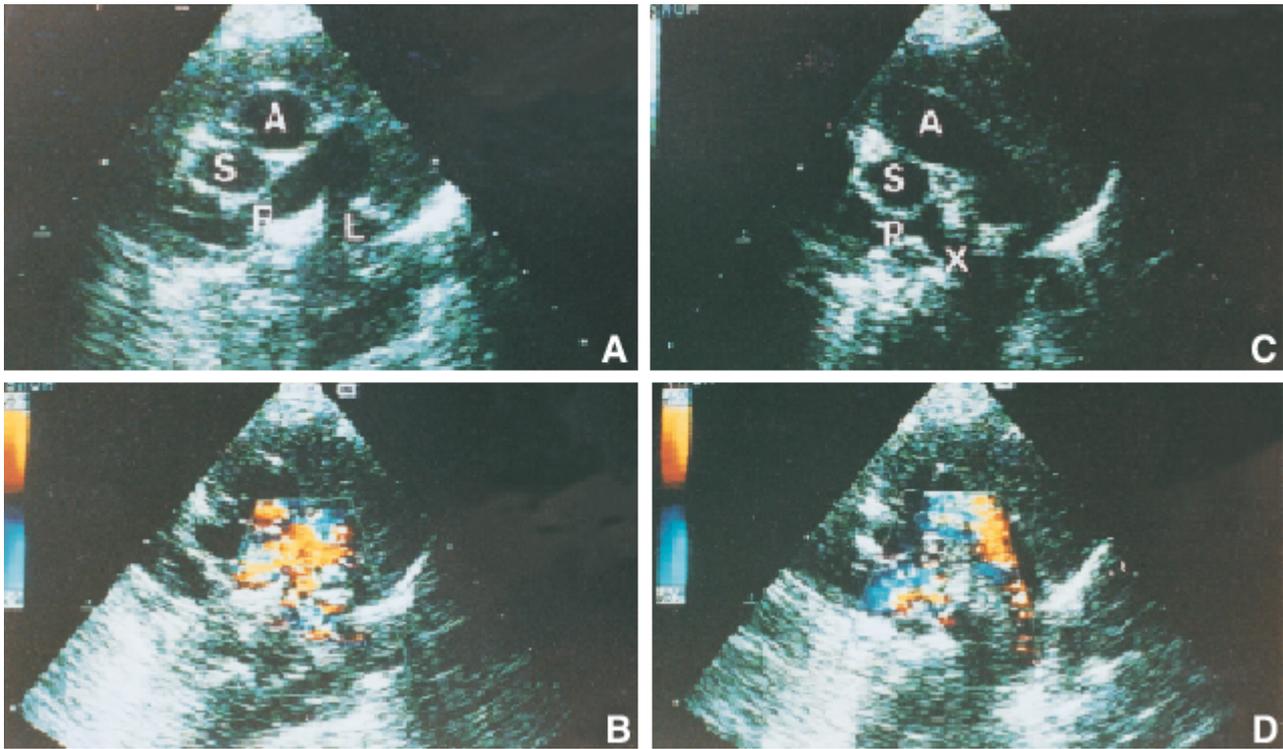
Echocardiogram from the parasternal short axis view demonstrates normal and anomalous left pulmonary arteries arising from the right pulmonary artery. A. Right and left pulmonary arteries originate normally. B. Color Doppler demonstrates normal flow in both pulmonary arteries. C. Aberrant left pulmonary artery rises from the right pulmonary artery distal to the normal bifurcation site of the left pulmonary artery. D. Color Doppler demonstrates flow through aberrant left pulmonary that courses behind the trachea. A, aorta; S, superior vena cava; R, right pulmonary artery; L, left pulmonary artery; X, aberrant left pulmonary artery.
